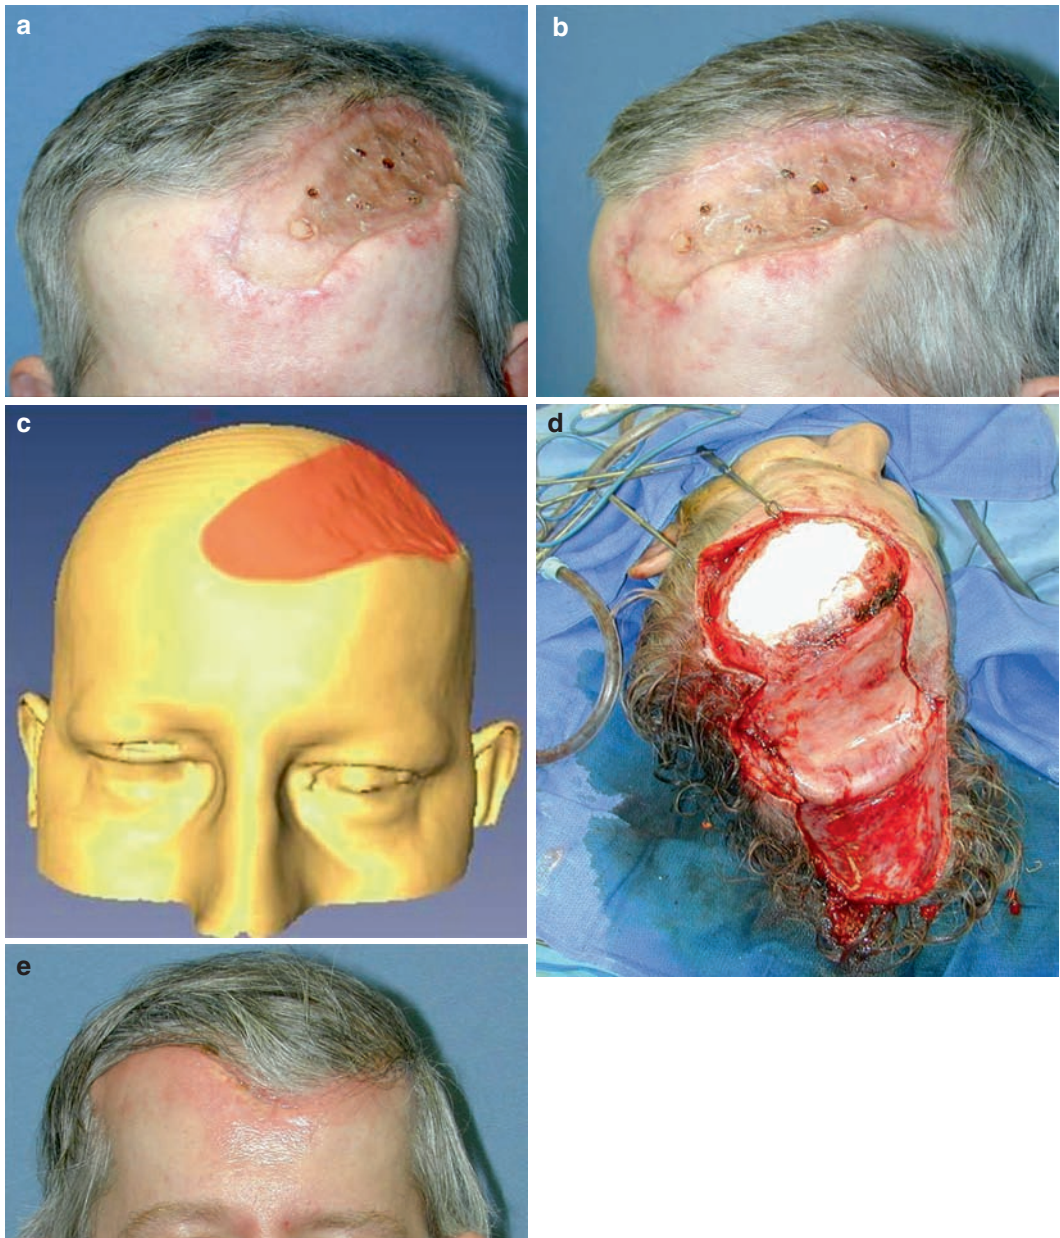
(a) Anterior view of post-traumatic calvarial defect in a 48-year-old male. (b) The same patient is seen from an oblique angle. (c) Preoperative assessment of the calvarial defect included high-resolution, three-dimensional computed tomography to quantify the size of the defect. (d) Intraoperative view of the application of the BoneSource bone cement to the calvarial defect after first stage tissue expansion of the adjacent scalp. (e) Postoperative result after recontouring of the calvarium with bone cement and advancement of the expanded adjacent scalp soft tissue. (Photographs courtesy of Dan Medalie, MD.)
